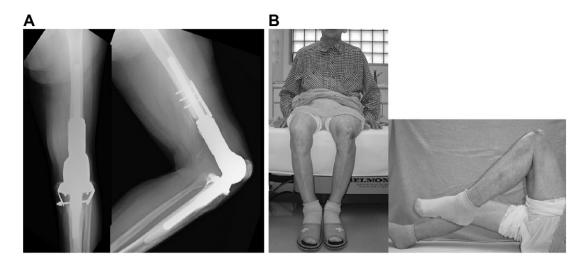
(A) Radiographs at the latest follow-up, 4 years postoperatively, that showed no radiolucent lines around the femoral and tibial components; (B) knee range of motion was maintained from 0° to 110°.
